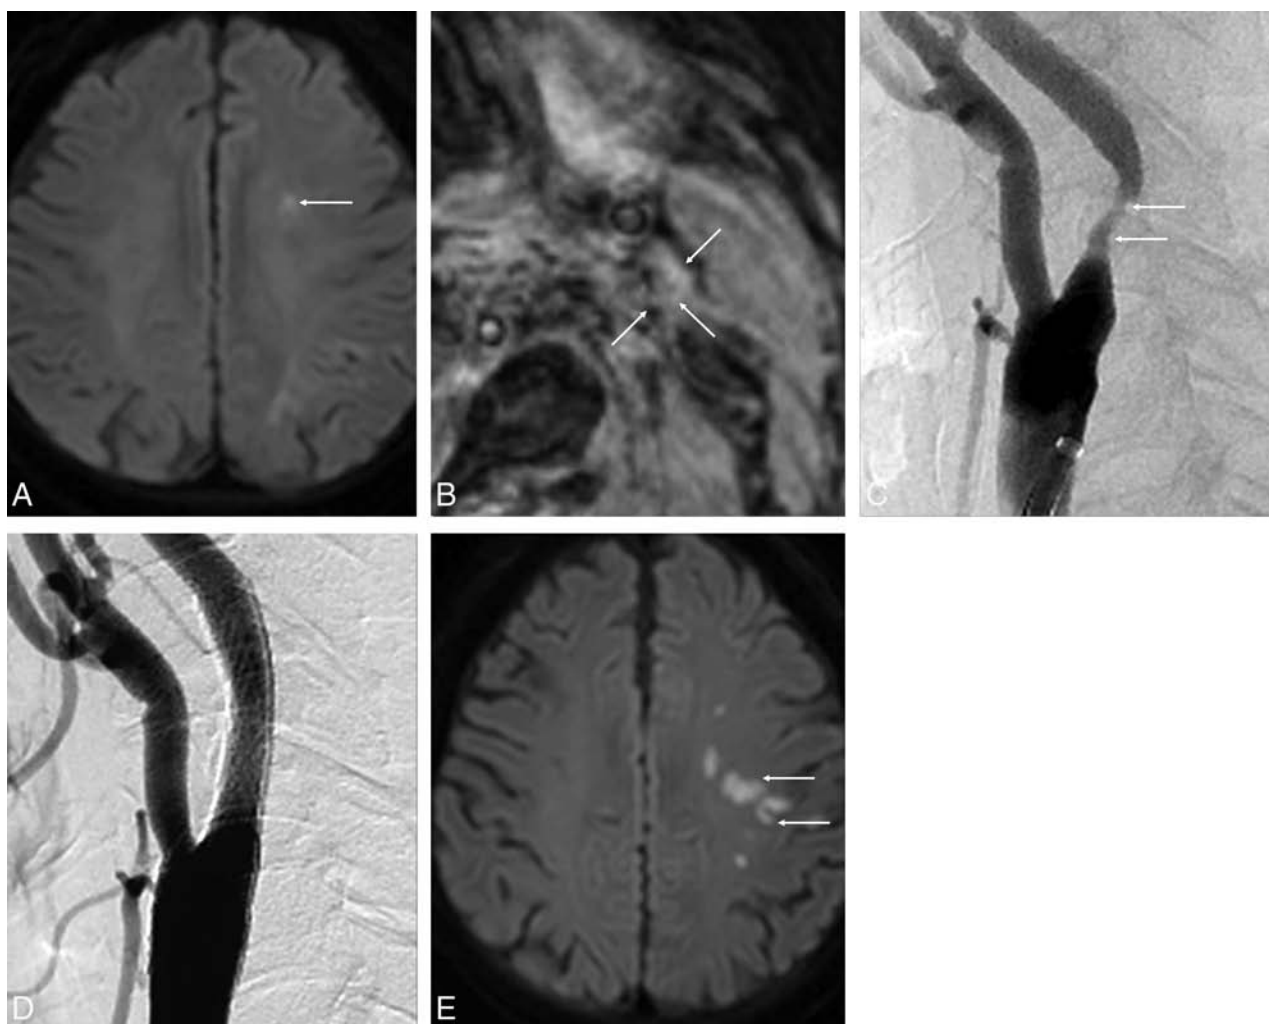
A 77-year-old man with a left acute embolic infarction due to severe stenosis of the left proximal internal carotid artery. *A*, Axial DWI at admission shows multiple areas of diffusion restriction in the left centrum semiovale (arrow). *B*, MPRAGE image shows isointensity of the left carotid plaque (arrows). This finding indicates a necrotic core without IPH. *C*, Lateral projection of left carotid angiography shows moderate stenosis in the proximal cervical portion of the left internal carotid artery (arrows). *D*, Carotid artery angiogram after protected CAS shows complete recanalization without residual stenosis. *E*, Axial DWI after CAS shows the new embolic lesions in the left frontal lobe (arrows).
